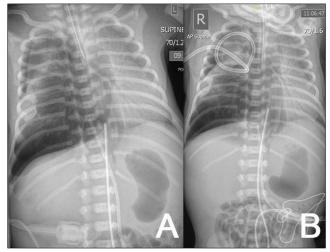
Chest and abdominal radiographs showing right-sided pneumothorax (first diagnosis) – before (A) and after (B) drain 1.
